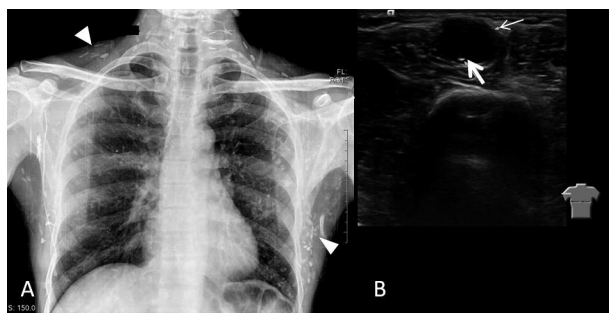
A. Frontal radiograph of the chest shows multiple ovoid calcified lesions (arrowheads) in the soft tissues of the chest wall and neck. B. Ultrasound reveals a cystic lesion (thin arrow) with hyperechoic scolex (thick arrow) in the right upper arm.
